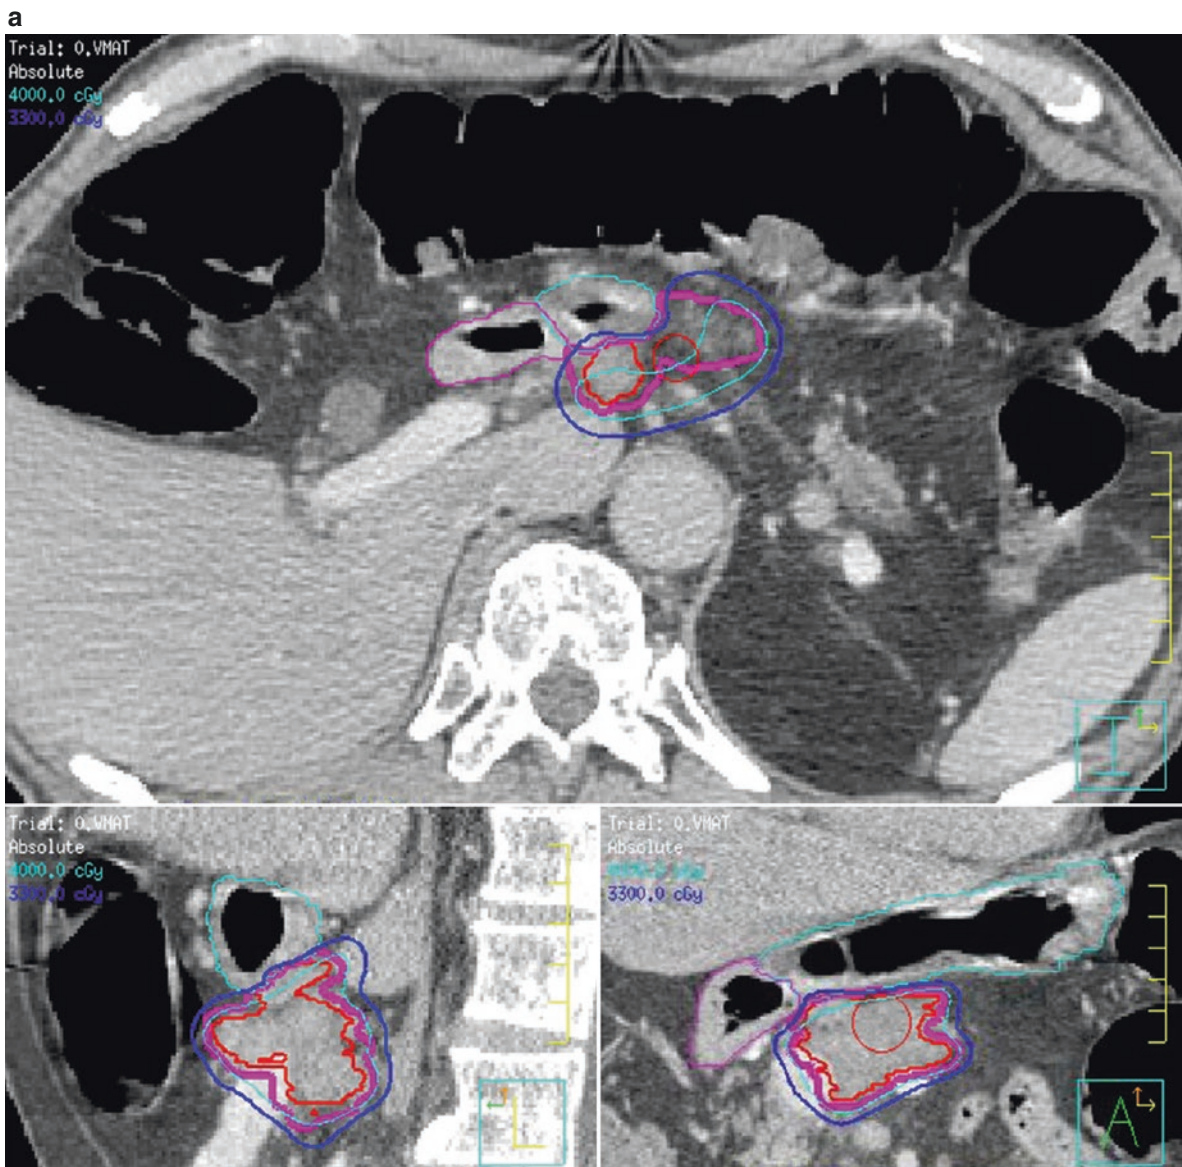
(a) Planning CT scan for a pancreatic SBRT plan to deliver 40 Gy in five fractions to the modified PTV excluding the stomach and duodenum. (b) Cone-beam CT for the same patient at the time of the third treatment fraction, with considerable luminal organ distention.
